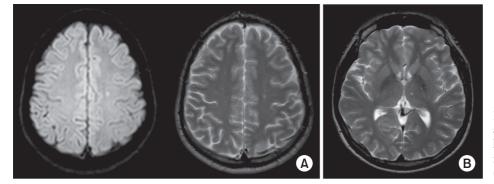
Brain magnetic resonance image. Hyper-intense foci are seen in the left centrum semiovale on T2-weighted image (A) and diffusion-weighted images (B).
